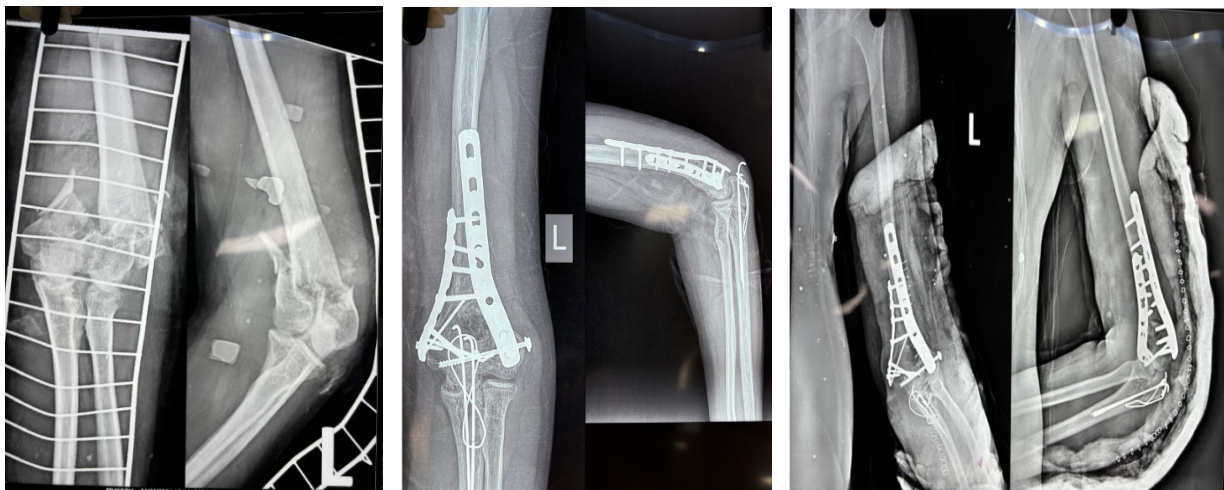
Preoperative and postoperative X-ray
